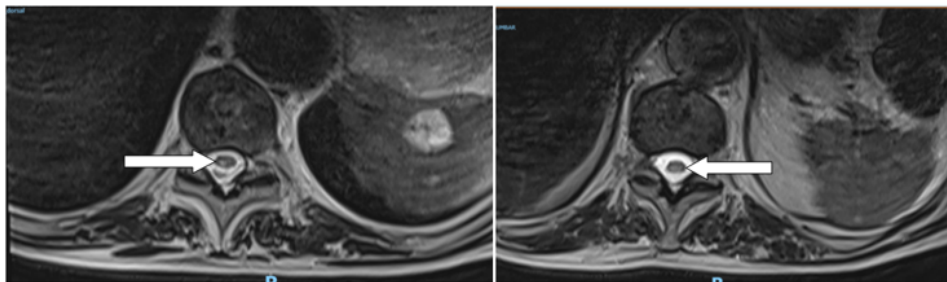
Axial MRI shows an axial view of the same infarct.
